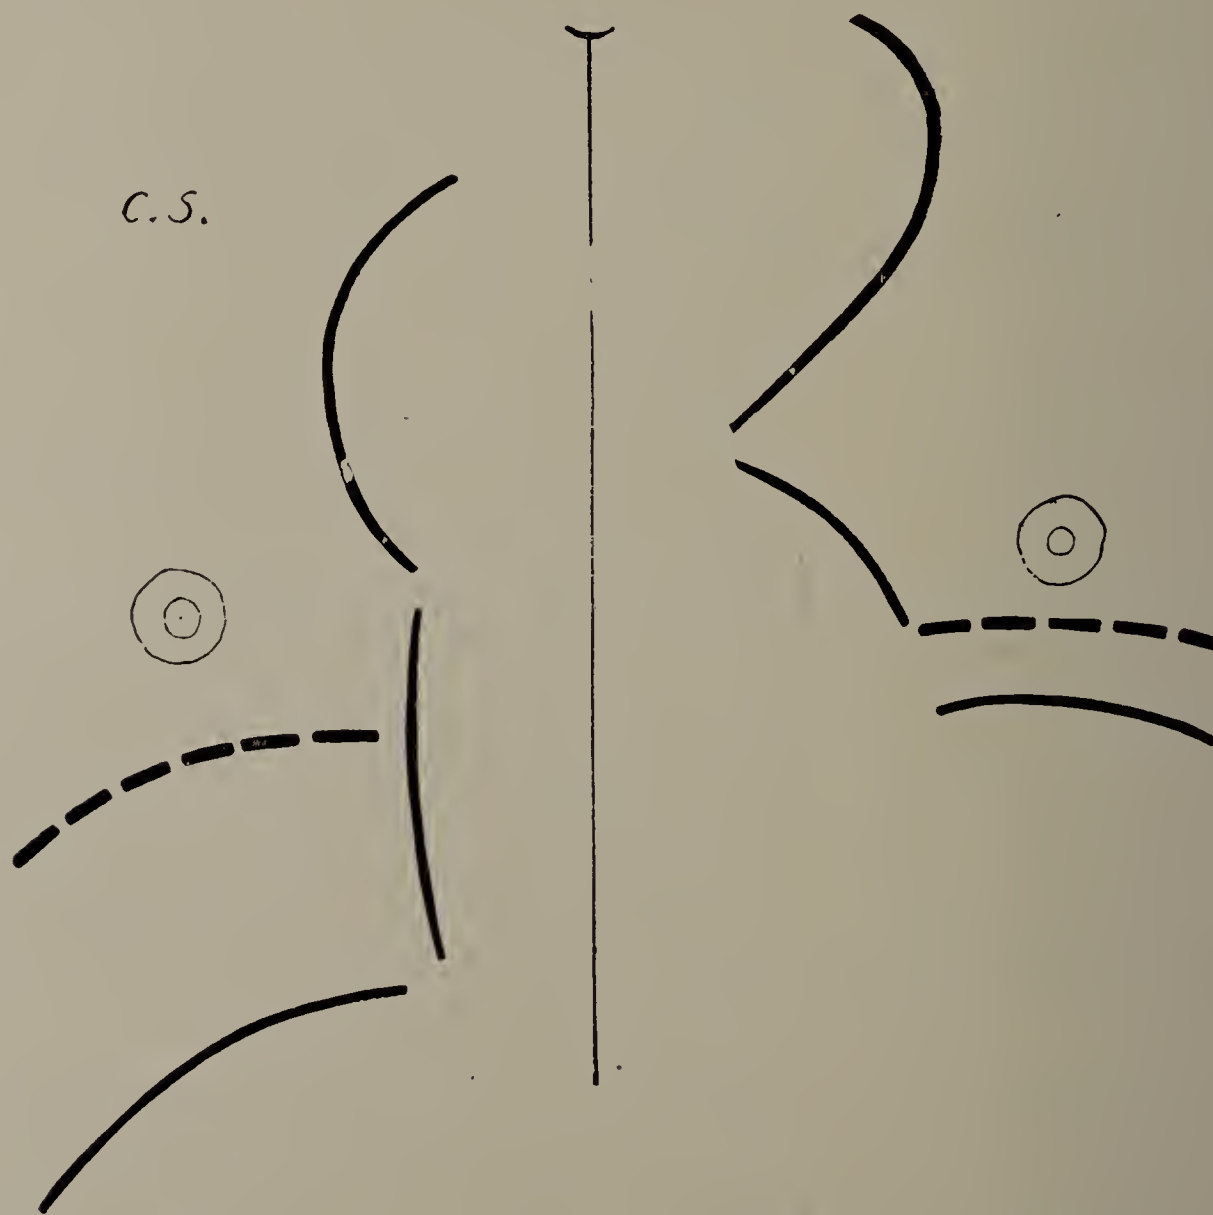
Case IV. C. S. Cut of X-ray tracing. The greater portion of the aneurism is to the left of the sternum, though it also extends to the right side. The excursion of the diaphragm on the left side is much less than on the right. (Cut one-third life size.)
